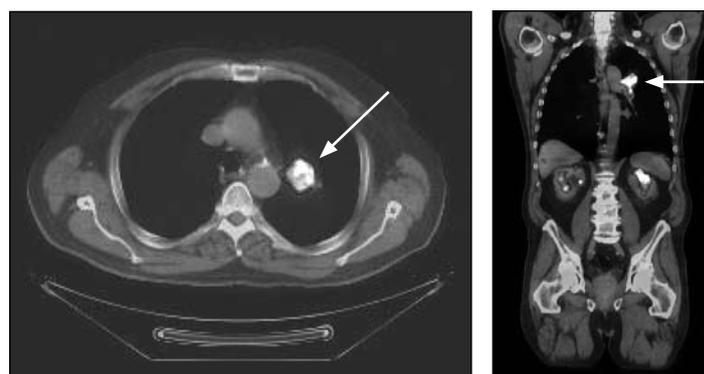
A PET (positron emission tomography) scan shows the functional status of the body tissues and so highlights neoplastic tissues with a high rate of metabolism. Scans may be combined with CT images to reconstruct three dimensional images
